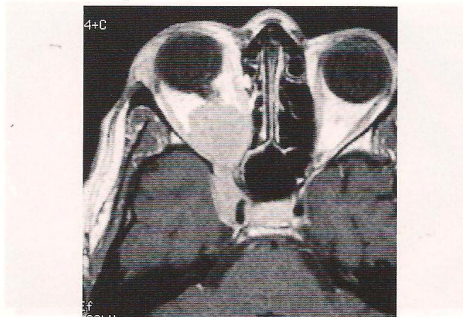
Coronal magnetic resonance imaging in T1-weighted image of the patient shown in Fig. 5-29 revealing a round mass arising from the posterior aspect of the optic nerve with extension through the optic canal into the chiasm. The tumor was resected via a transcranial route.
